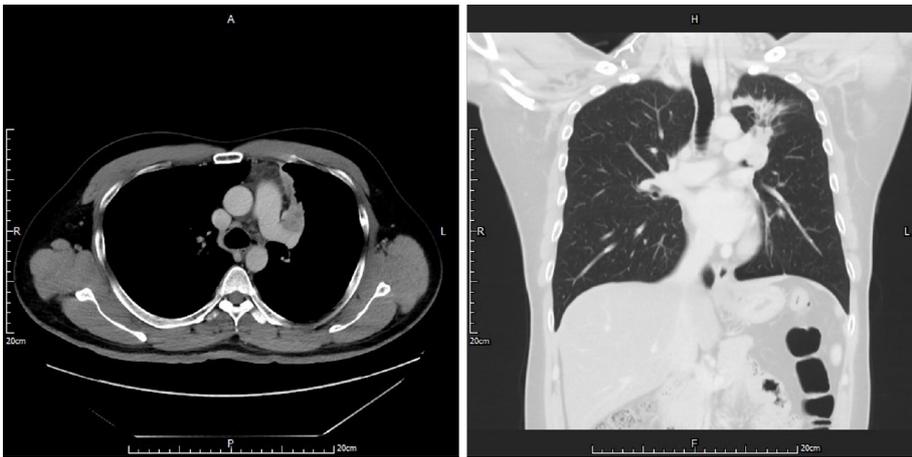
Chest computed tomography showed a tumor located in the left upper lobe of the lung with suspected endobronchial lesions and obstructive pneumonitis. Vessel invasion could not be excluded.
